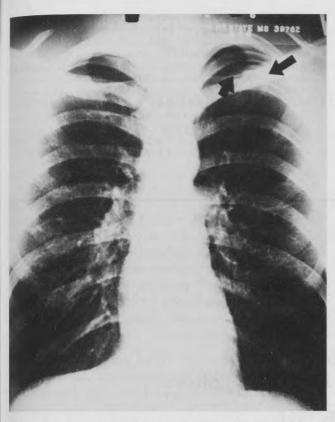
Posterior-anterior chest radiograph. The pleural line in the left upper lung field at T-4 posterior (indicated by arrows) shows the pneumothorax.
